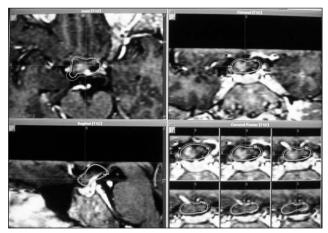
Snapshot image of the second patient (glioma) taken during Gamma Knife treatment planning. Images showing axial, coronal, sagittal and coronal poster T1-weighted MRI views of a gadolinium-enhanced enlargement suggestive for a glioma within the right side of the optic chiasm, and isodose lines around the mass.
